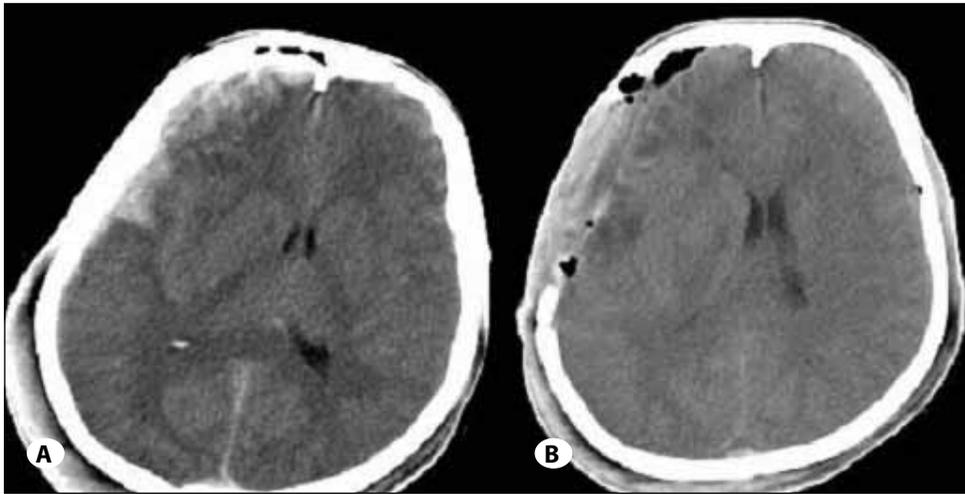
Pre- and postoperative CT scan of patient who underwent type II strategy. (A) Preoperative CT scan showing extensive contusion in right frontal lobe and compressed ventricles. (B) Postoperative CT scan indicating decreased compression of the ventricles after DC combined with resection of the contusion tissue.
